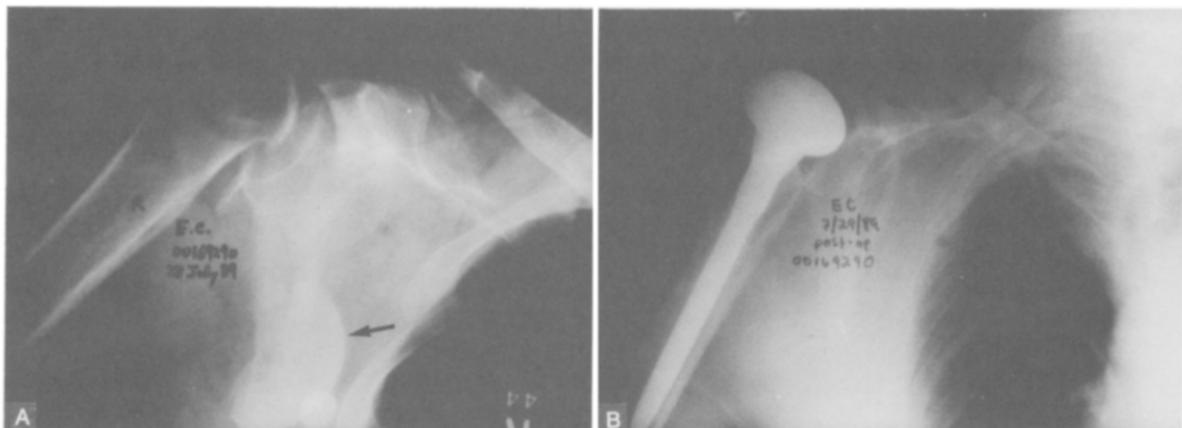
Sixty-five-year-old man who was injured by motor vehicle accident. Axillary, radial, and ulnar nerves were also injured. A, Initial anteroposterior radiograph shows anatomic neck fracture-dislocation with severely displaced humeral head (*arrow*). B, Hemiarthroplasty was performed. Radial and ulnar nerves recovered in 3 months. Axillary nerve had not recovered at 6 months, when he died in another motor vehicle accident.
